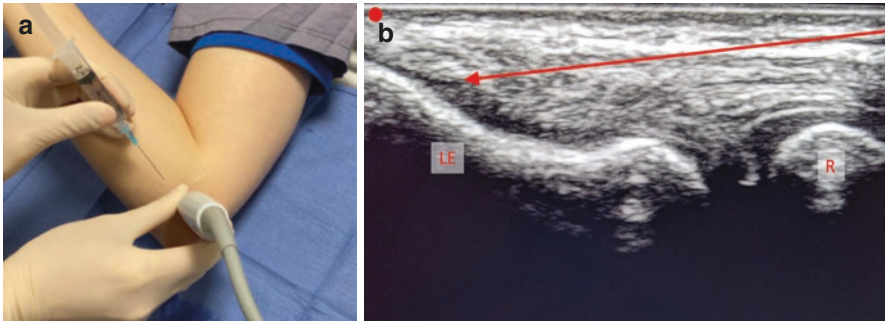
(a) Needle approach for lateral epicondyle injection with ultrasound guidance. (b) Corresponding ultrasound image for lateral epicondyle injection. The red arrow represents the proposed needle approach via in-plane technique. Red dot = Proximal; *LE* lateral epicondyle, *R* radial head
